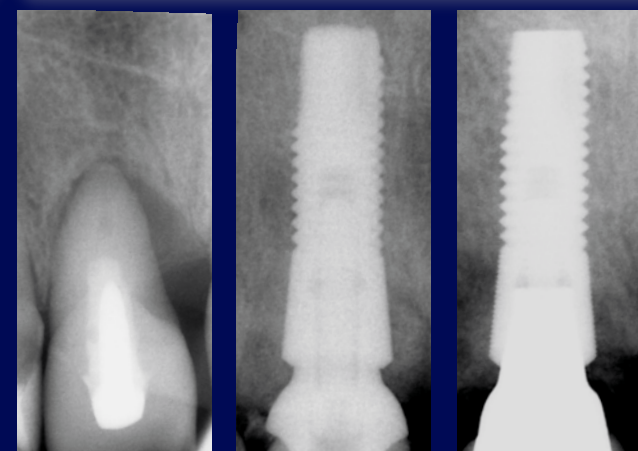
l & m: Radiographs pre-op, at insertion and at 2-year.
